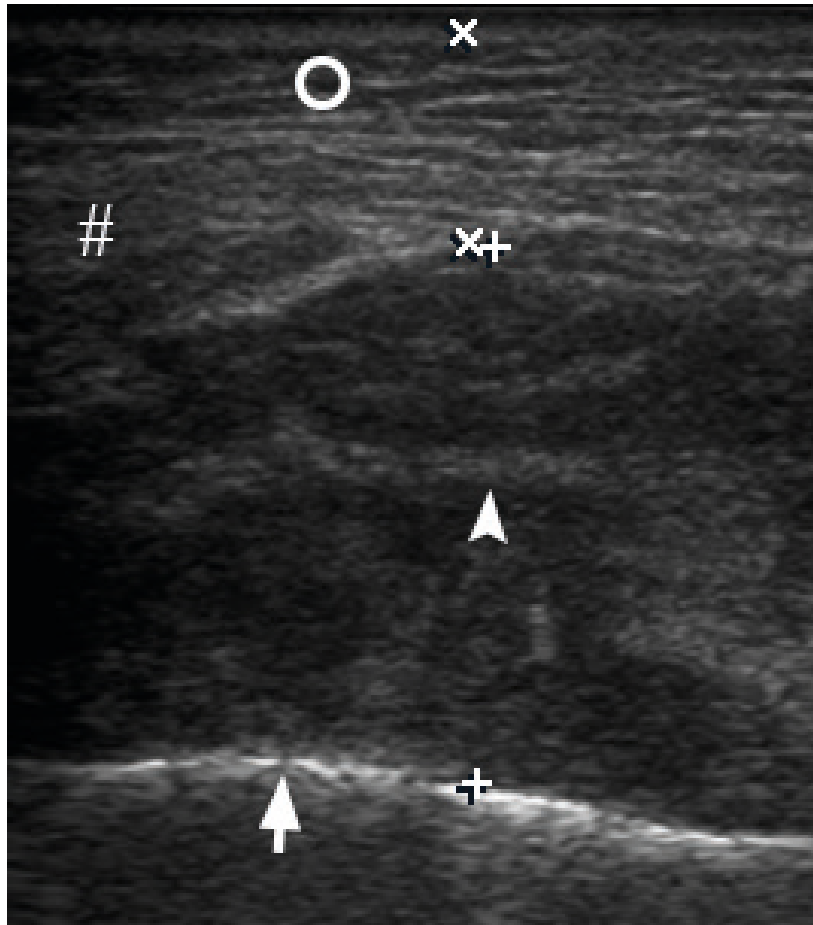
Transverse gray scale ultrasound demonstrates a swelling of the right masseter muscle (is indicated by two '+' calipers) up to 2.08 cm and subcutaneous cellular tissue (is indicated by *circle*) up to 0.8 cm. Notes dissociation of masseter fibers (*arrowhead*) by small amounts of hypoechoic fluid (purulent content). Outer surface of the mandibular ramus is indicated by *arrow* and parotid gland – by *hashtag*. Printed with permission and copyrights retained by O.S.C. and I.I.F.
